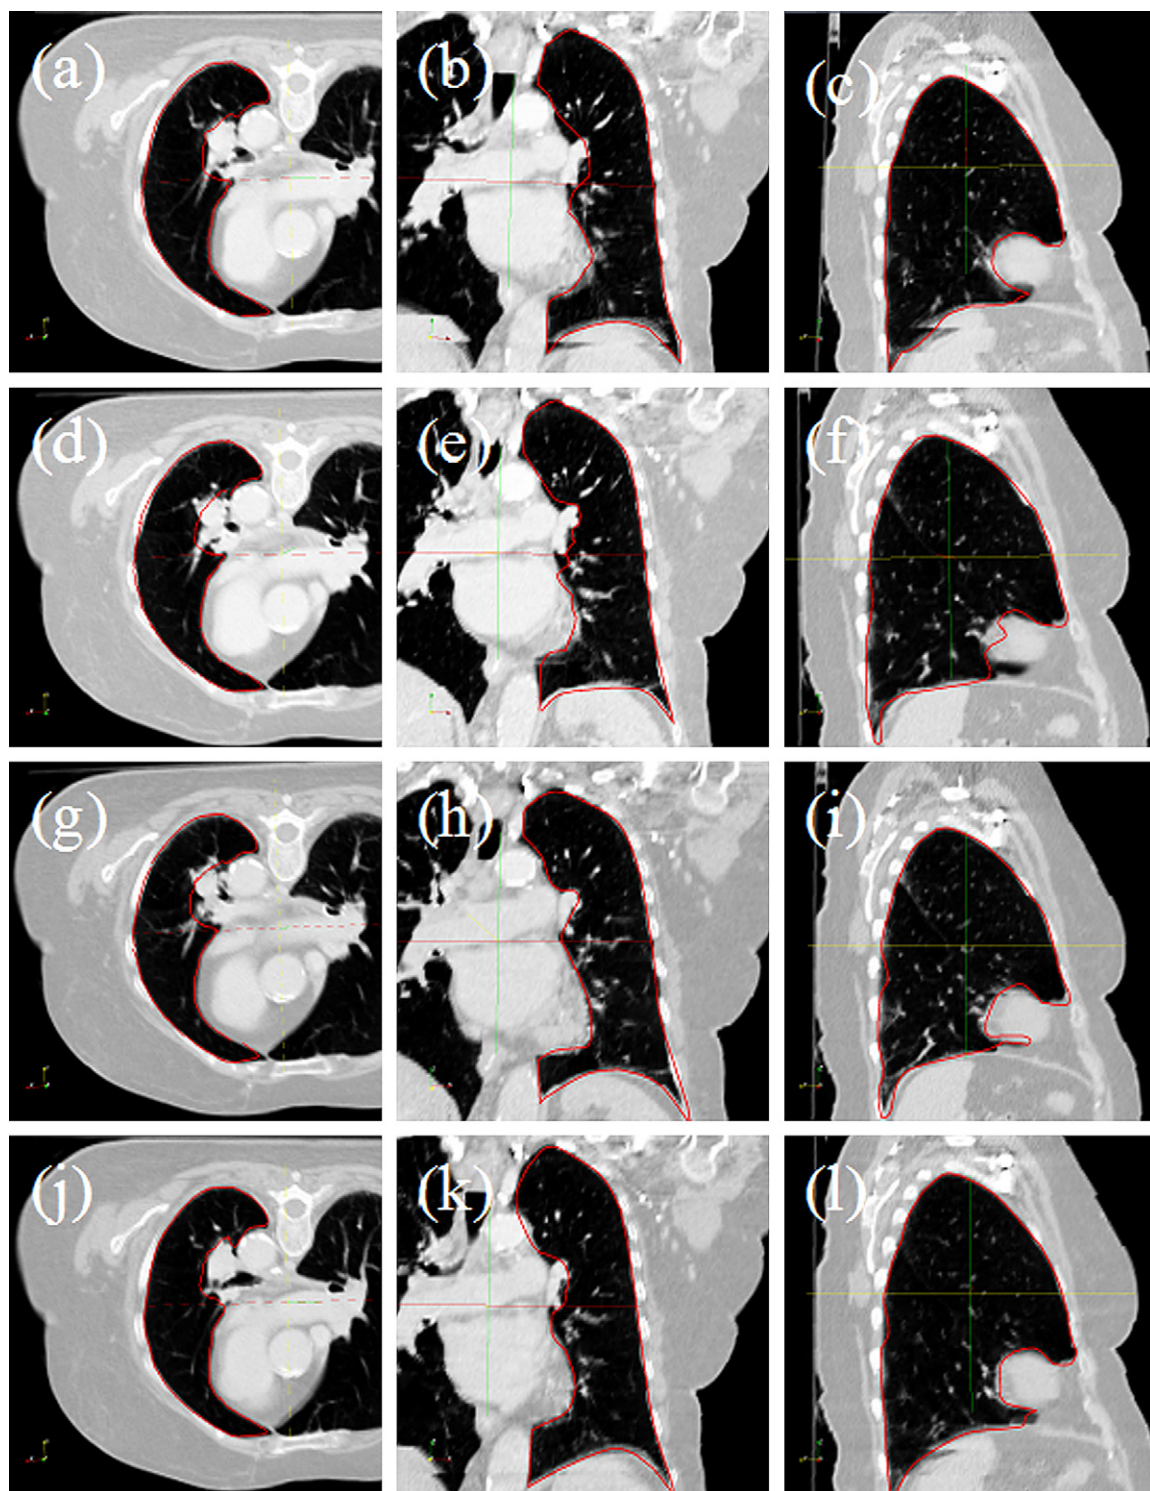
Computed tomographic images and mapped contours for thoracic patient 1. Displayed are selected phases. From the top row to bottom, phases 2, 6, 8, and 10 are presented, respectively. For each phase, transverse, coronal, and sagittal views are shown from left to right.
